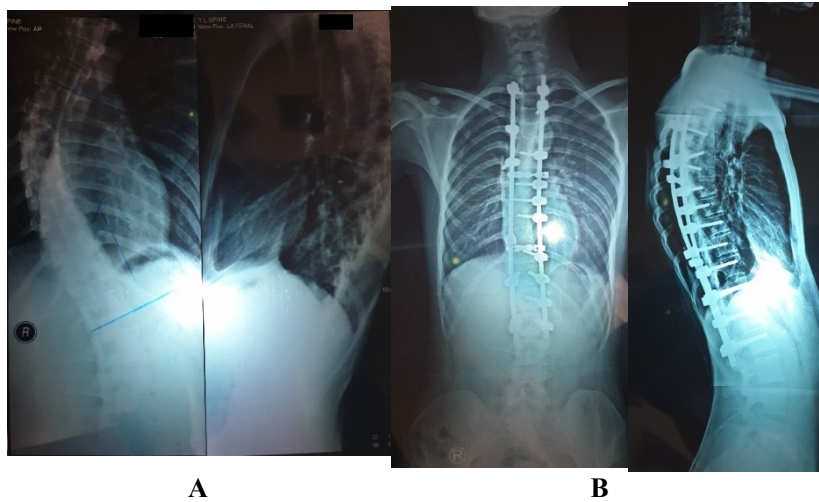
Patient number 10 (male patient, surgery at 16 years old). The radiographs showed that the Cobb angle (2A) pre-operative (50°) and (2B) post-operative (26°) difference was 24° .
